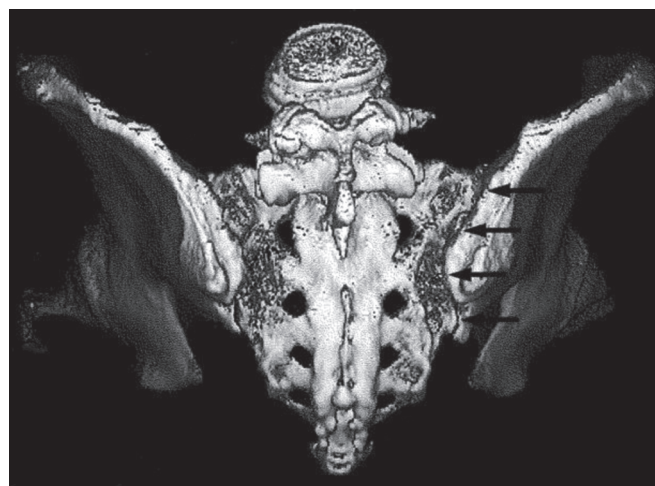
CT scan of sacroiliac joint from front
